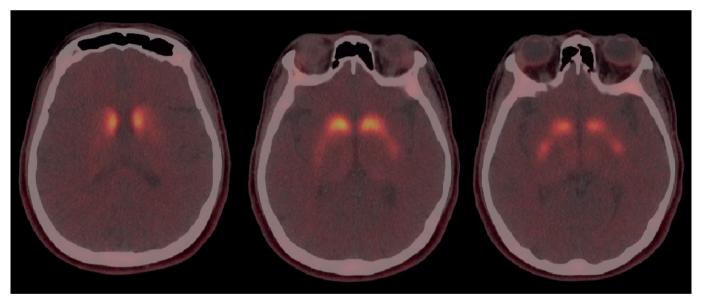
Finding of brain dopamine transporter PET imaging. Hypometabolism in the bilateral putamina and posterior caudate nuclei was noted in fluorine-18-FP-CIT PET-CT images.
